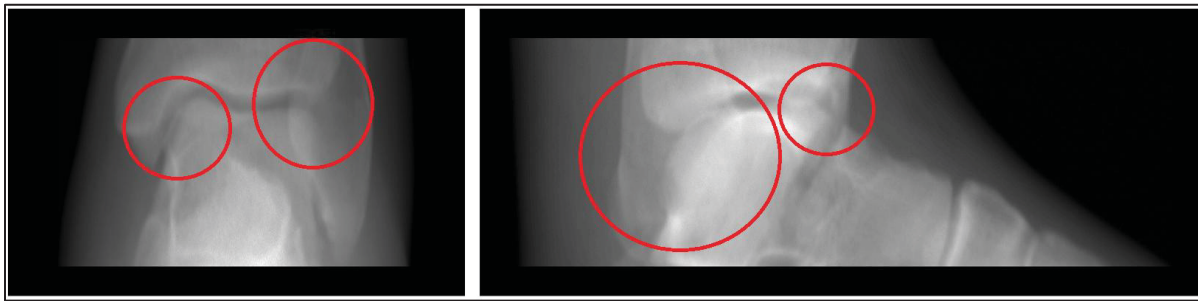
AP and LT radiographs of ankle indicating superposed tibia, fibula and talus
